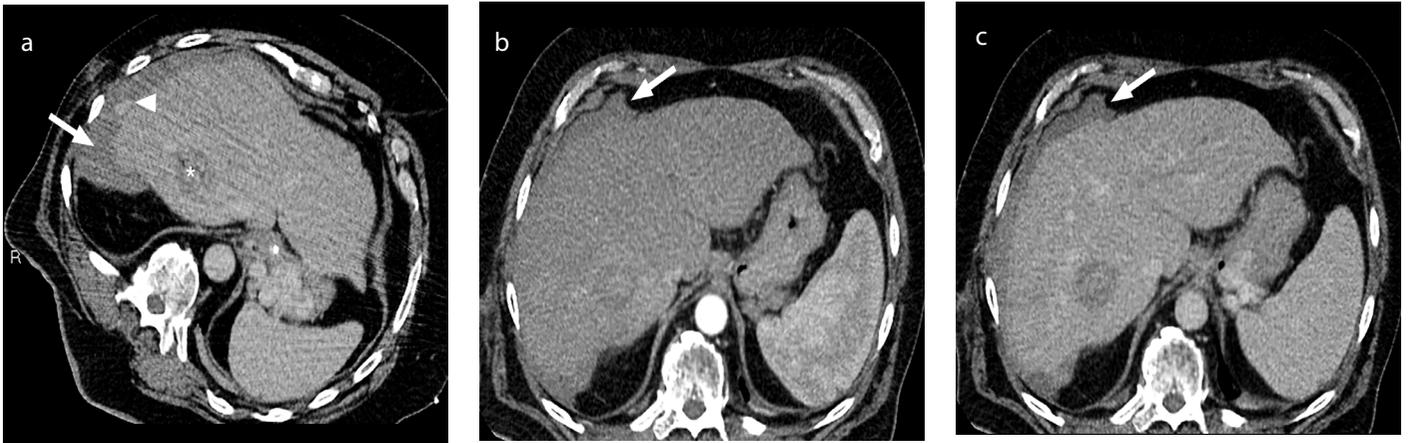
(a-c) Perihepatic hematoma after microwave ablation of a segment 7/8 hepatocellular carcinoma. Axial contrast-enhanced computed tomography (CECT) image (a) showing a perihepatic hematoma (arrow) with a focus on extracapsular contrast extravasation (arrowhead) seen only in the venous phase due to bleeding. Site of ablation (asterisk). The patient's hemodynamic status remained stable and unchanged during close monitoring. Repeat axial CECT images in the arterial (b) and venous (c) phases two hours post-procedure demonstrate a stable perihepatic hematoma (arrow) with the disappearance of the contrast extravasation.
